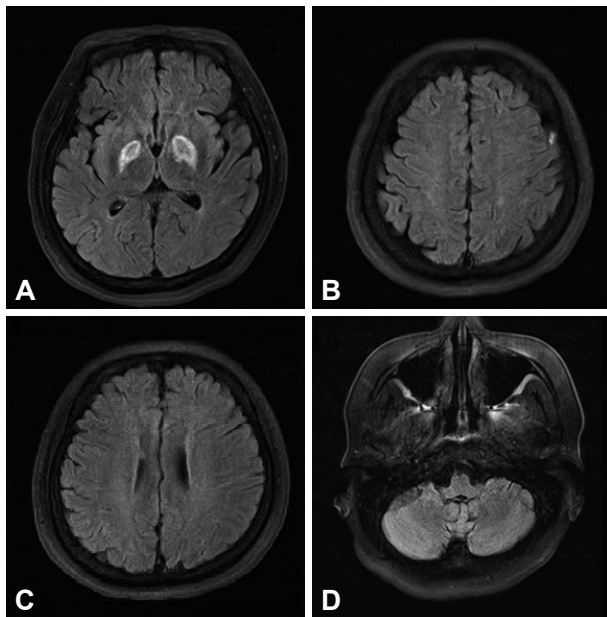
Follow-up fluid attenuated inversion recovery MRI after the 20 days of symptoms onset revealing hyperintense lesions in bilateral globus pallidi, which had seen diffusion-weighted brain MRI on admission (A). The fronto-parietal subcortical white matter and left inferior cerebellar hemisphere lesion are not shown any more (B, C, D).
